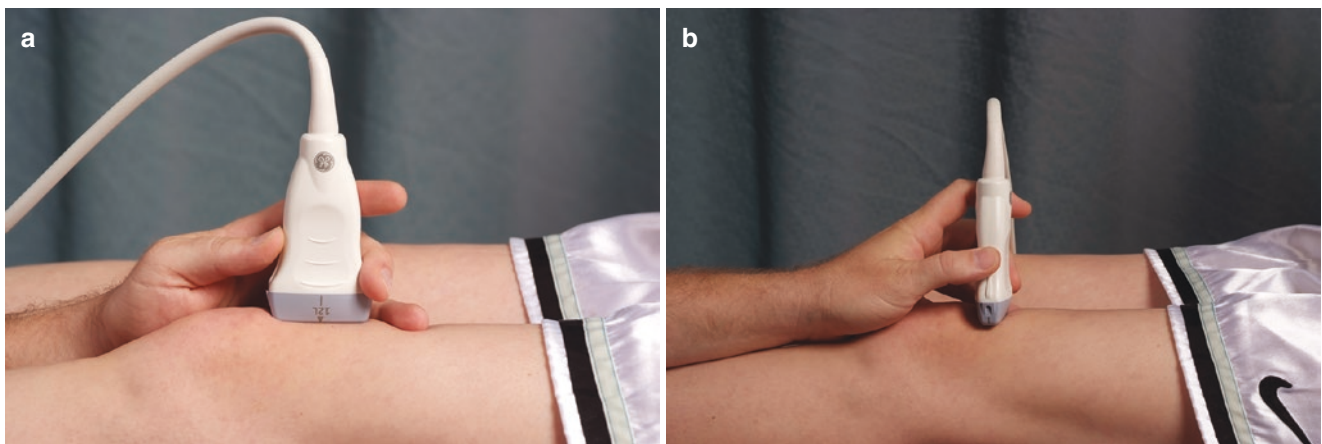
(a, b) Proper handling of an ultrasound probe
